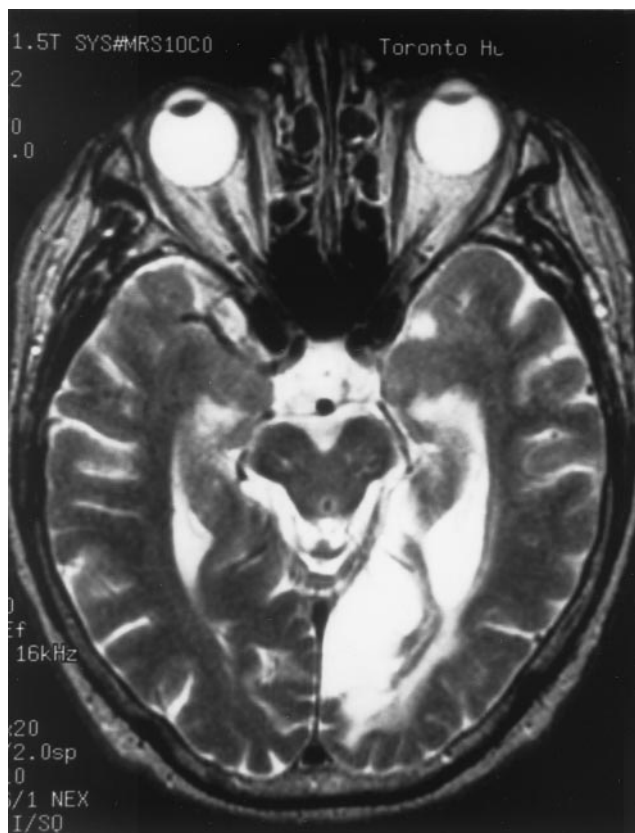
Axial T2-weighted MR image of patient 3 showing an infarct in the left mesial occipital cortex, with sparing of the occipital pole.
